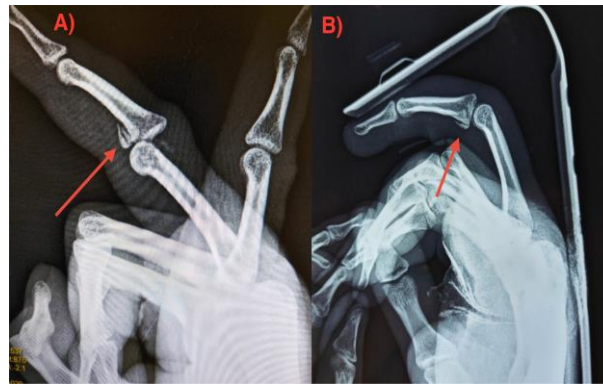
Radiographs of A 25-Year-Old Male with Right Ring Finger Injury.
